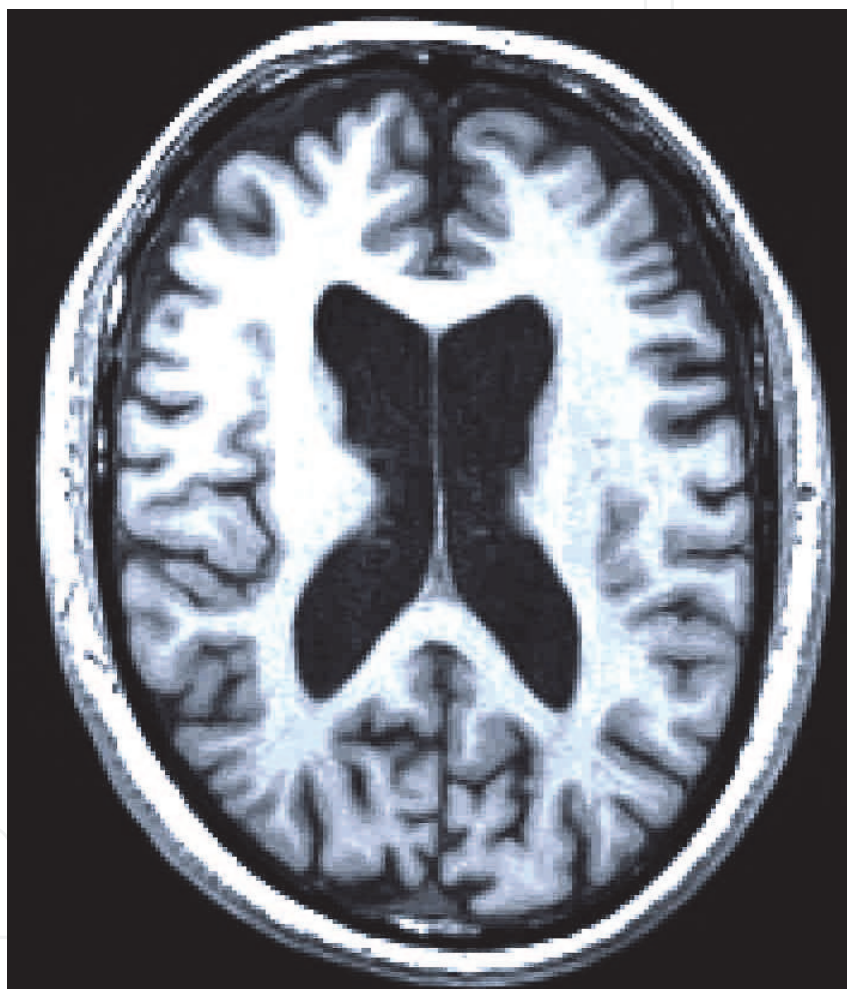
MRI scan showing atrophy of the brain in Huntington's Disease (courtesy of Joakim Tedroff and Mouna Esmaeilzadeh).
